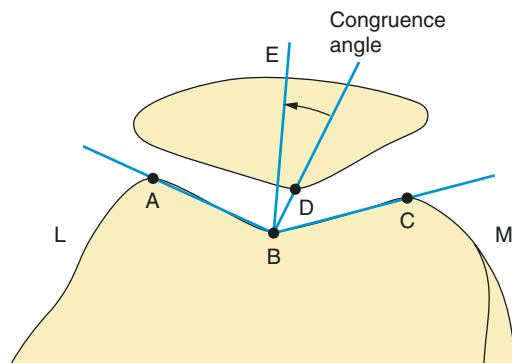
Measurement of the congruence angle on an axial radiograph of the knee. First, the sulcus angle is measured (AB/BC) and bisected to form a reference line (BE). The line BD is drawn from the deepest point of the interarticular sulcus of the trochlea to the deepest point of the interarticular ridge of the patella. The congruence angle is measured between BD and BE
